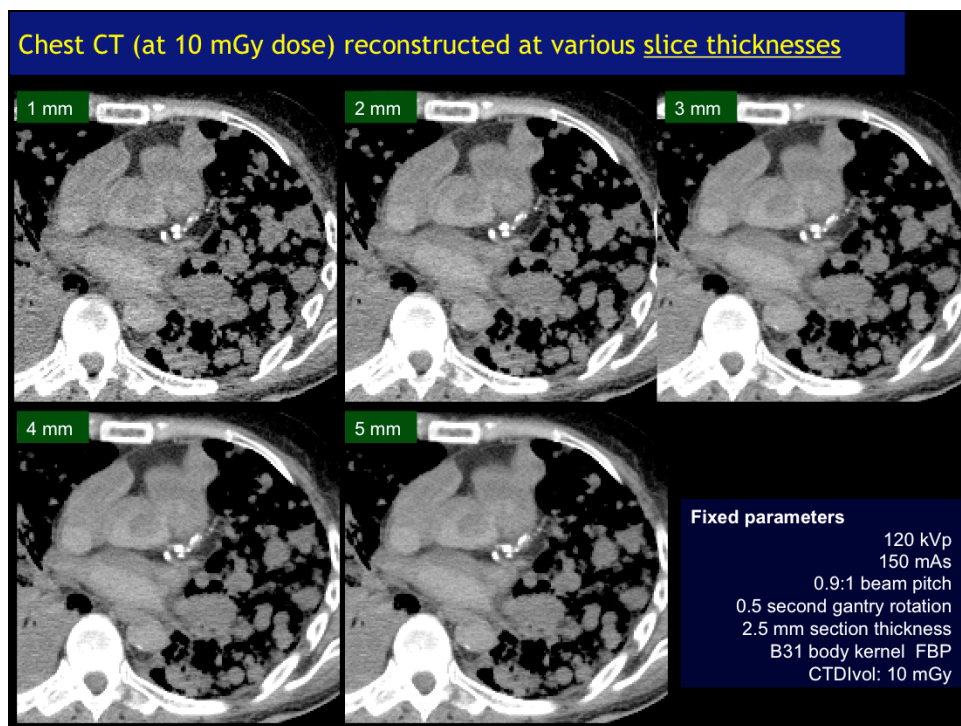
Transverse chest CT images (mediastinal windows) acquired at 150 mAs (CTDIvol 10 mGy)
